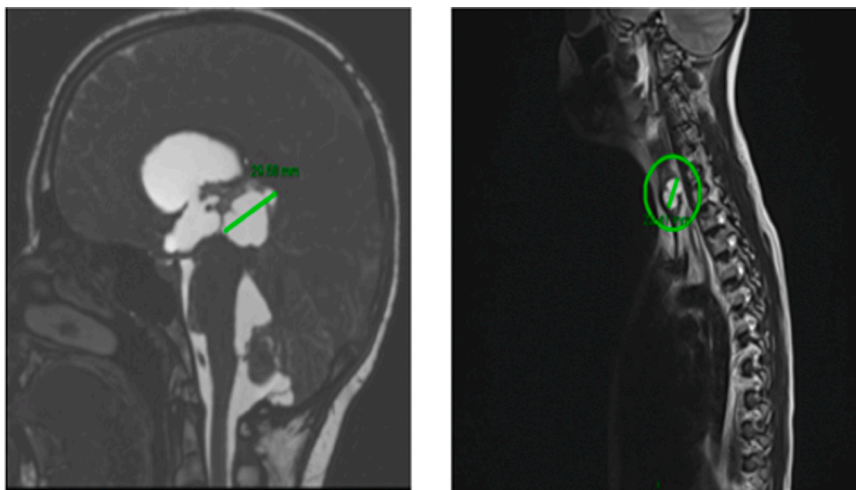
MRI demonstrating pineal gland lesion and spinal imaging demonstrated cystic changes within the thyroid gland in Child 3.
